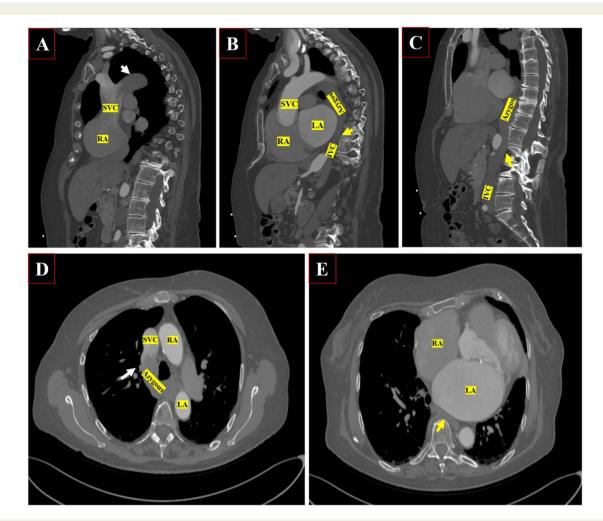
Sagittal and cross-sectional view contrast-computed tomography of the chest and the abdomen before the procedure. Note the enlargement of the azygos vein before draining to the superior vena cava (white arrow A and D) compressed by an enlarged left atrium (yellow arrow B and E) and the interruption of the inferior vena cava at the hepatic segment (yellow arrow C). CT, computed tomography; IVC, inferior vena cava; LA, left atrium; RA, right atrium; SVC, superior vena cava.
